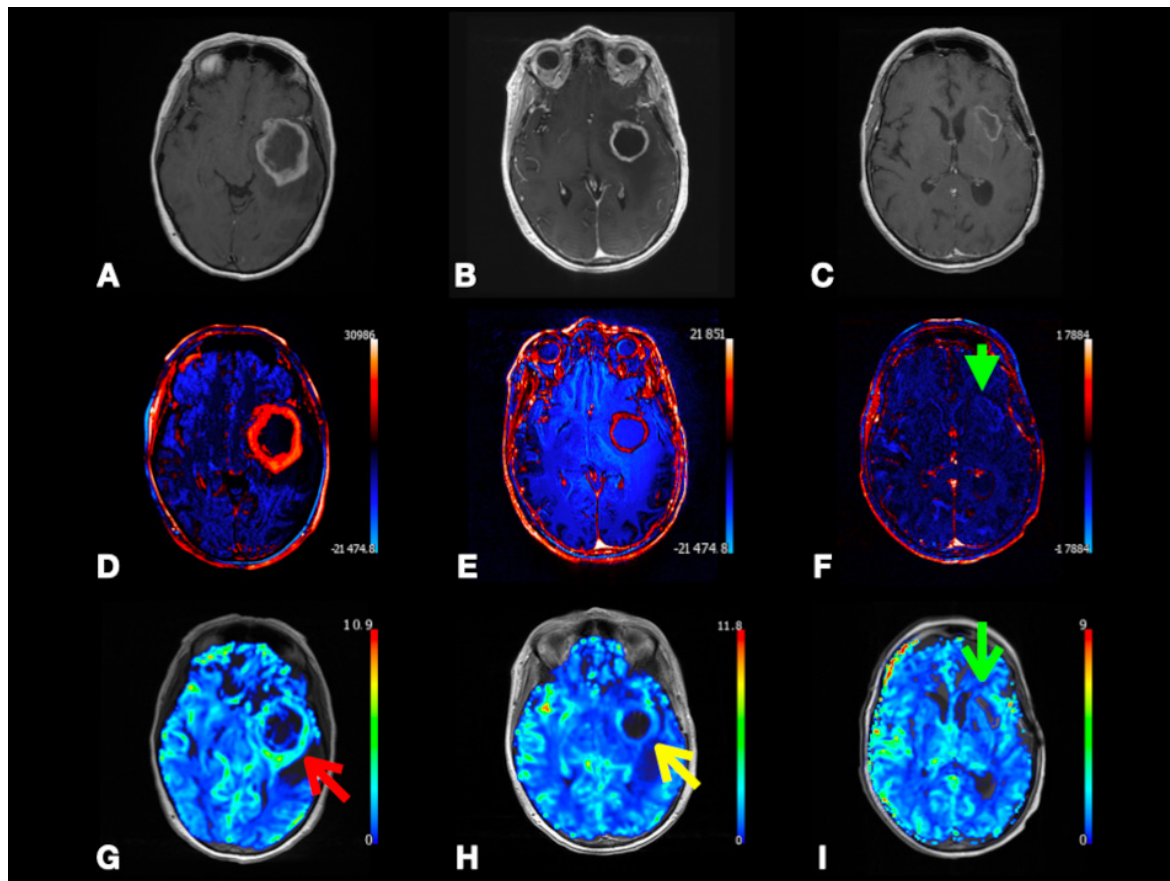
Left temporal lobe glioblastoma (WHO Grade 4) with false-positive perfusion imaging for recurrence and subsequent treatment-mediated response. Axial post-contrast T1-weighted (A–C), color-coded subtraction maps (D–F), and color-coded rCBV maps (G–I) from DSC data. Baseline images (A,D,G) depicting enhancing mass with central necrosis and peripheral hyperperfusion (red arrow). Images obtained four months later (B,E,H) depicting enhancement and hyperperfusion (yellow arrow) concerning for recurrence; subsequent redo resection with treatment effect and no tumor on pathology. Images obtained eight months later (C,F,I) after temozolomide and Avastin depicting T1 shortening, resolved enhancement (green arrowhead), and resolved hyperperfusion (green arrow) at the superior margin of the expanded resection cavity compatible with treatment response. Abbreviations: rCBV, relative cerebral blood volume; DSC, Dynamic susceptibility contrast MRI.
